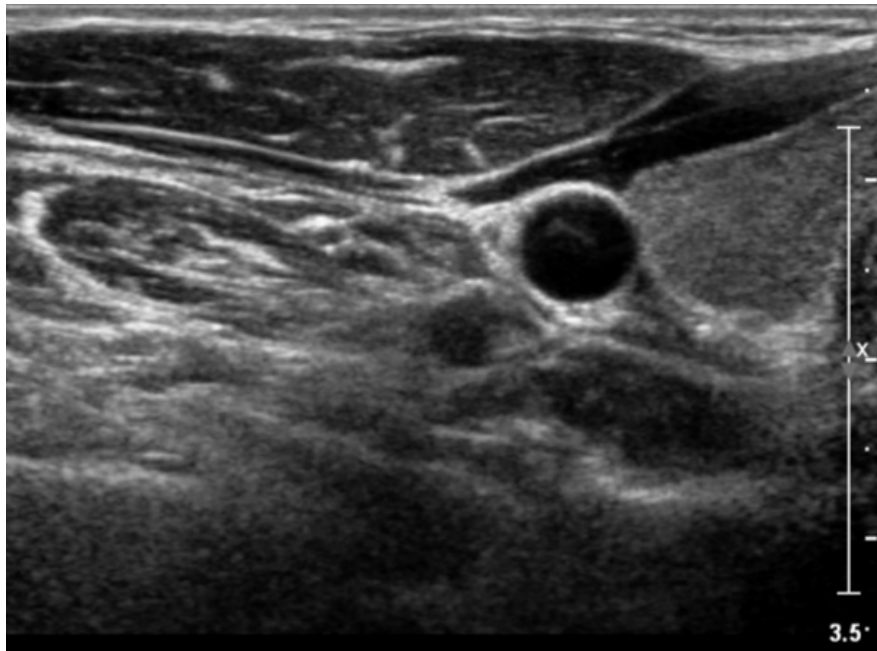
Ultrasound images showing a thick-walled oval intramuscular lesion with central cystic area containing irregular echogenic/thread like materials suggestive of cysticercosis in sternocleidomastoid muscle.
